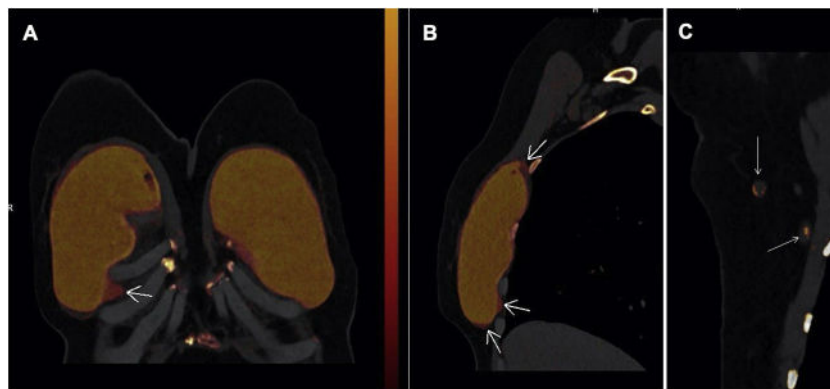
Rupture of right breast prosthesis. Dual energy CT scan without IV contrast (silicon map) as a consequence of photoelectric effect on silica material ($Z = 14$). A) Coronal plane showing silicon material outside the prosthesis (extracapsular rupture). B) Sagittal plane showing the rupture zones (arrows), both superior and inferior. C) Lymph node involvement due to accumulation of silicon related to the rupture (arrows).
